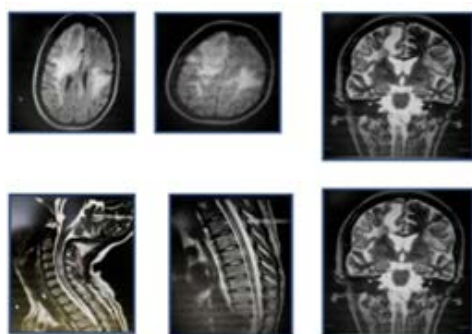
MRI Scan from 2022 admission showing multiple inflammatory lesions in the brain and also in the cervical-dorsal spinal cord.
